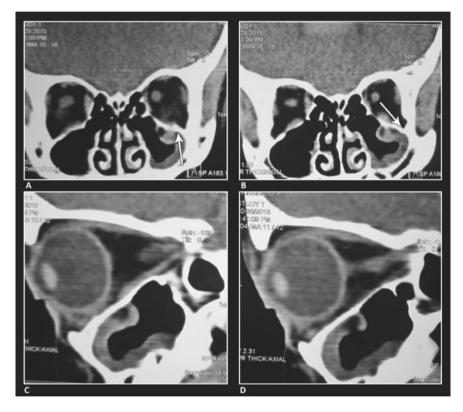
Inferior rectus muscle herniation into the maxillary sinus through the orbital floor trap door fracture (a). Notice that, the fracture line is completely closed (b) best demonstrated in sagittal view CT-scan (c, d)
